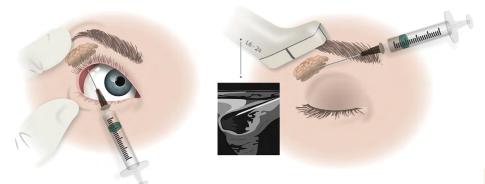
Injection methods into the lacrimal gland (LG). Left: Transconjunctival injection as performed in the safety study. Right: Transcutaneous injection using ultrasound imaging in which the LG can be identified as performed in the randomized clinical trial.
